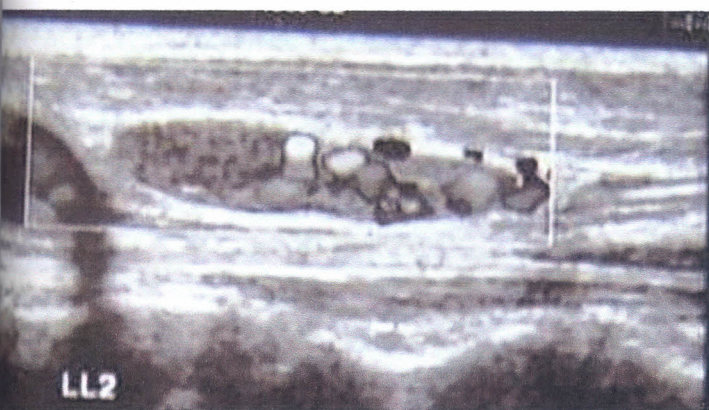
Gray –scale sonography of neck nodes . (a) Normal lymph node (with a large longitudinal diameter) adjacent major neck vessels;(b,d,f)-multiple nodes; (e) round shaped ($L/T < 2$) node
